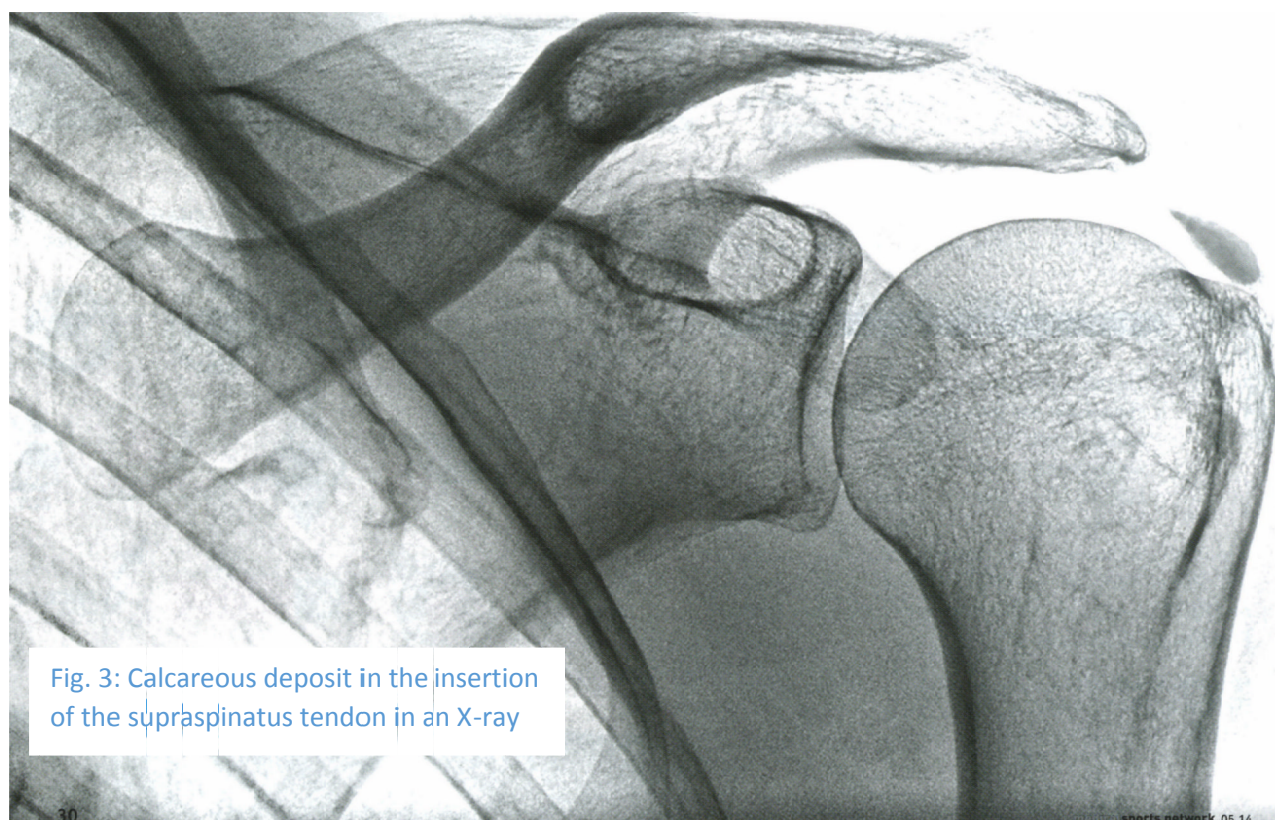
Calcareous deposit in the insertion of the supraspinatus tendon in an X-ray
